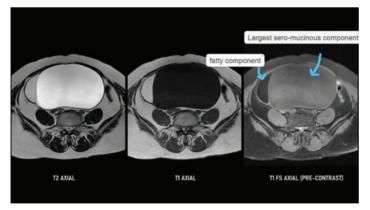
B T2 AXIAL, T1 AXIAL , T1 FS PRECONTRAST MRI IMAGES
